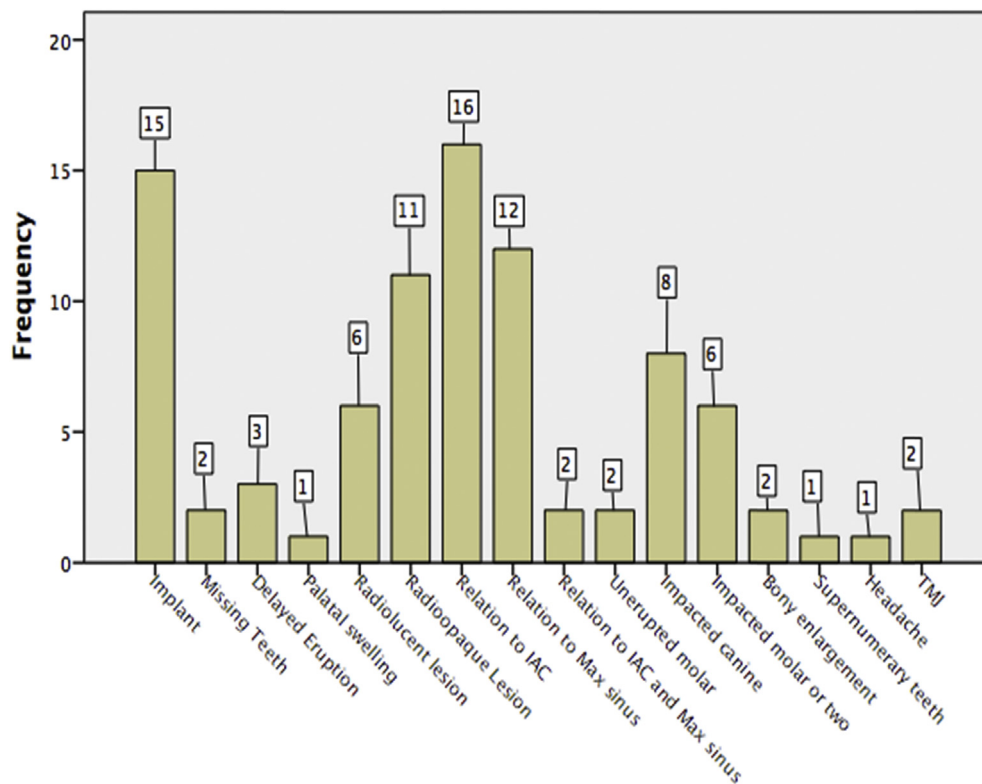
Indications for CBCT scans in the present study.
